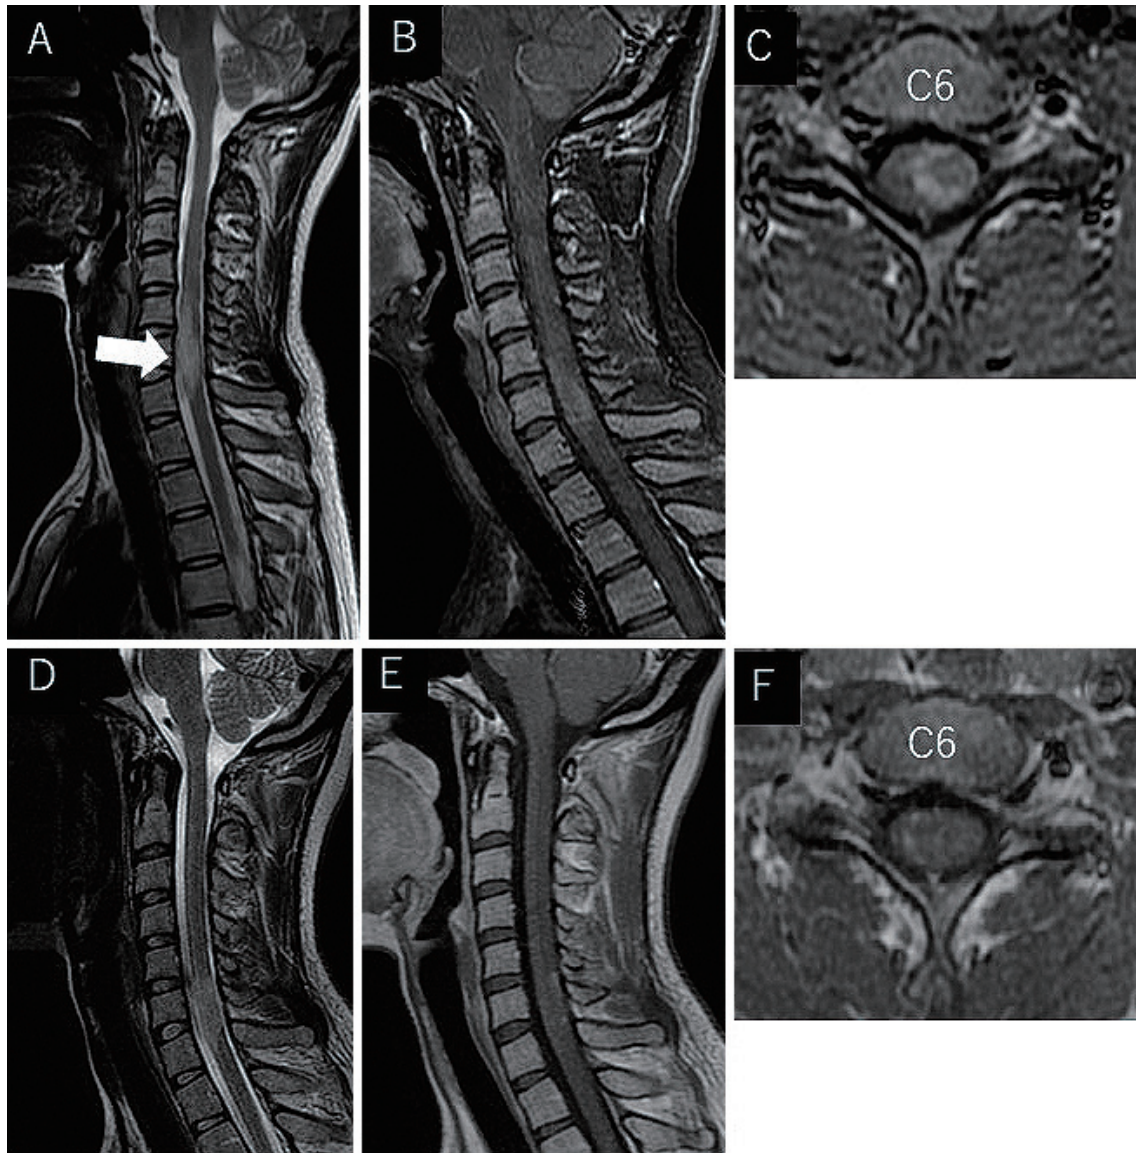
Initial magnetic resonance imaging (MRI) with contrast on admission. (A) T2-weighted and (B, C) post-contrast T1-weighted images showed spinal cord swelling with peripheral enhancement mainly located at the left-sided C5-7 levels (white arrow). Subsequent MRI with contrast medium after secondary intravenous methylprednisolone demonstrated regression of the spinal cord swelling and diminished enhanced lesions (D: T2-weighted, E, F: post-contrast T1-weighted images).
